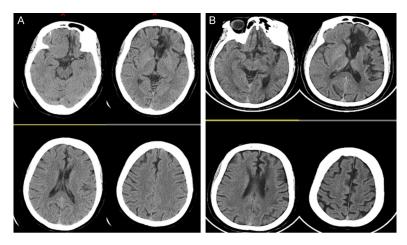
Head CT before and after the operation. A: Preoperative head CT; B: Head CT 3 months after the operation.
